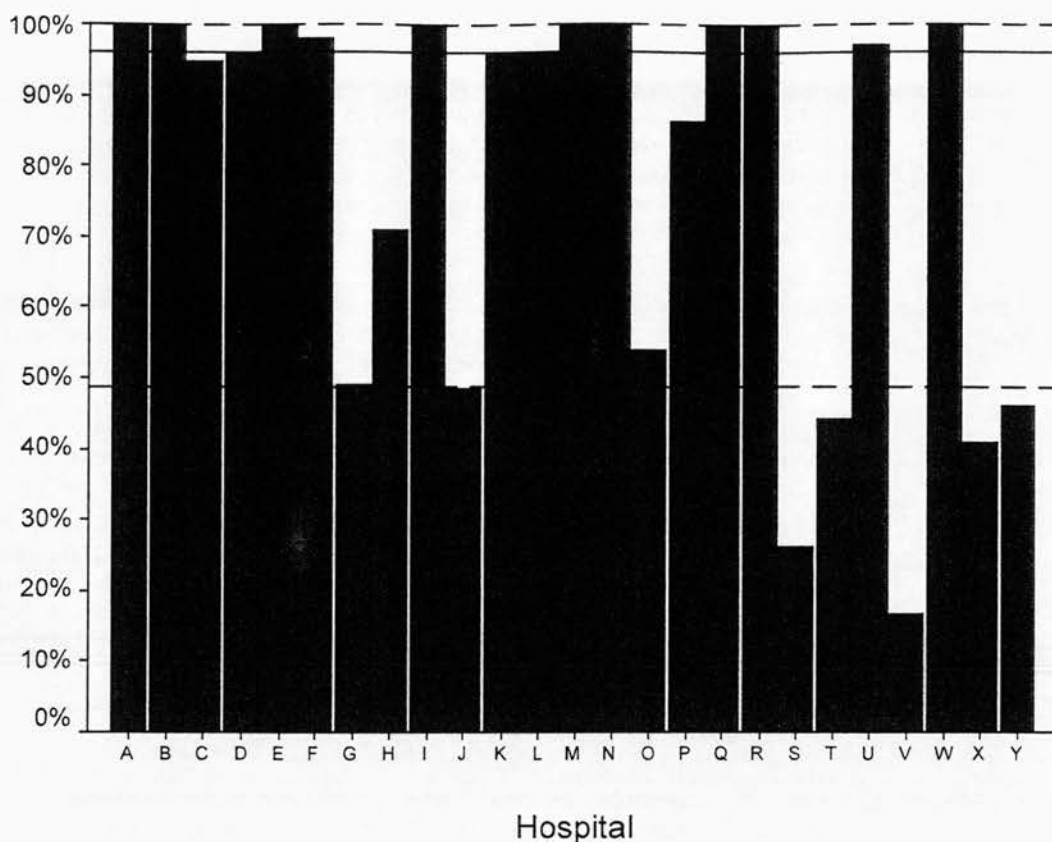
Percentage of women having ultrasonography performed.
